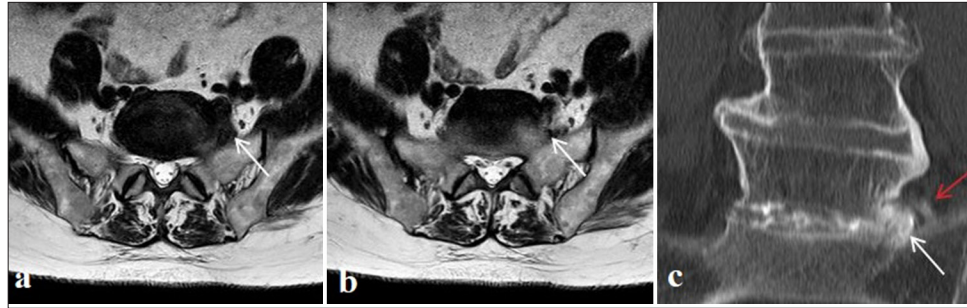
(a-c) Diagnosis of presacral luxation of a sequester (white arrows) on figures a,b,c, was confirmed by CT-discography with positive radiography of the displaced and compressed L5 - nerve root (red arrow) on figure c.
